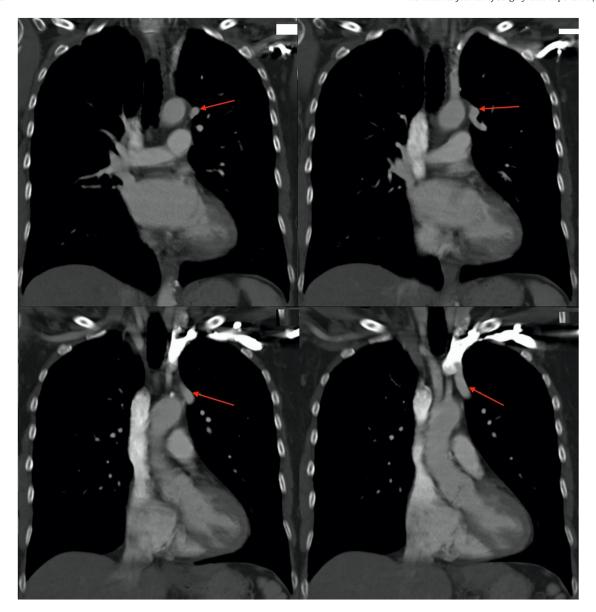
CT scan of patient's chest with red arrow demonstrating the left upper venous return directly to the left innominate vein.
